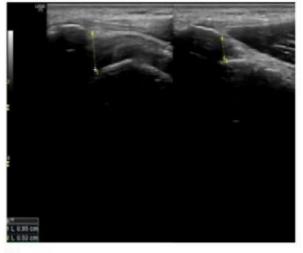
A MRI coronal STIR WI: bright signal intensity in the anterior direct fibers of the supraspinatus tendon denoting bursal surface tear (arrow). B static US shows linear hypoechoic defect involving the anterior direct tendinous fibers of the supraspinatus tendon (arrow).C dynamic US shows narrowing of the subacromial tunnel, which was increased in stress position.
